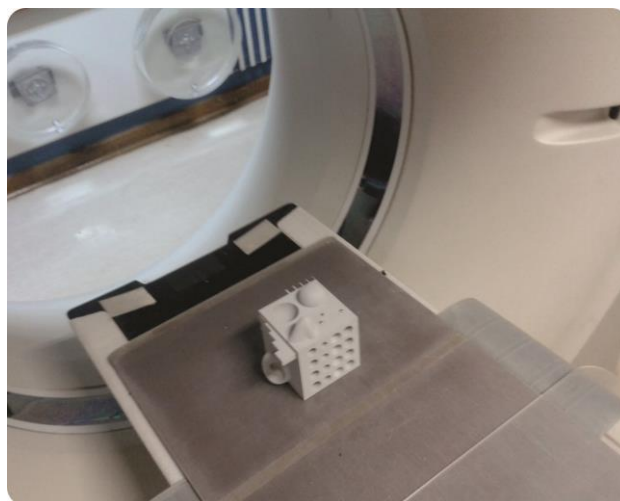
The Second Test Model positioned for CT scanning.
